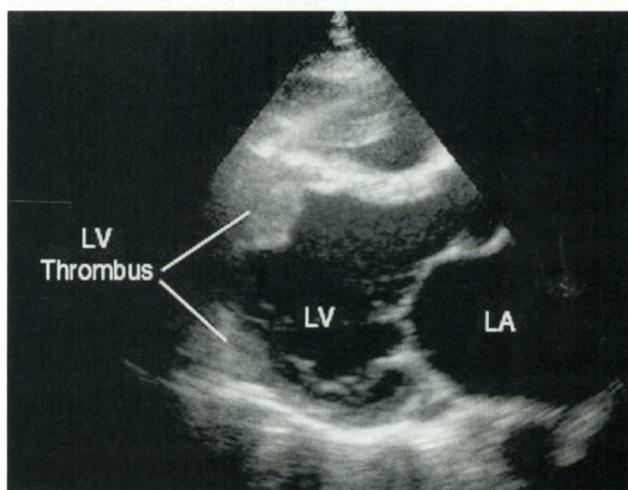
A left ventricular thrombus is located near the apex (parasternal long-axis view). LV = left ventricle, LA = left atrium.
